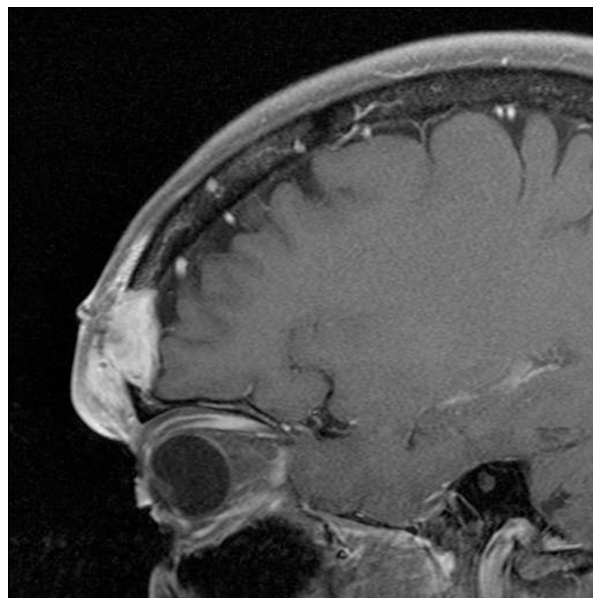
Plasmacytoma. Sagittal T1-weighted magnetic resonance imaging scan demonstrating tumor invasion through left frontal bone.
